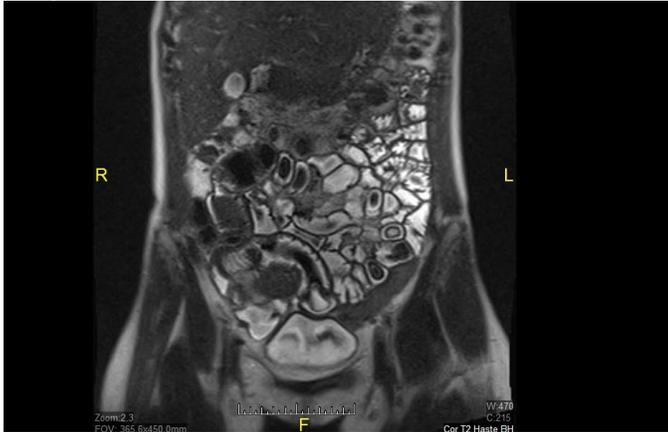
MRI enterography.
